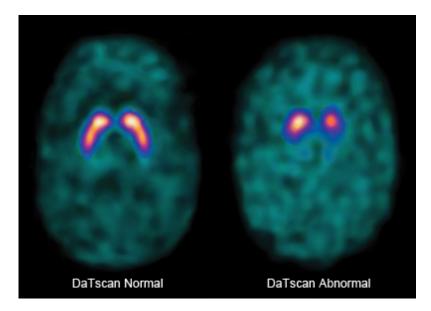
An example of a normal and a pathologically altered FP-CIT-SPECT [41].
